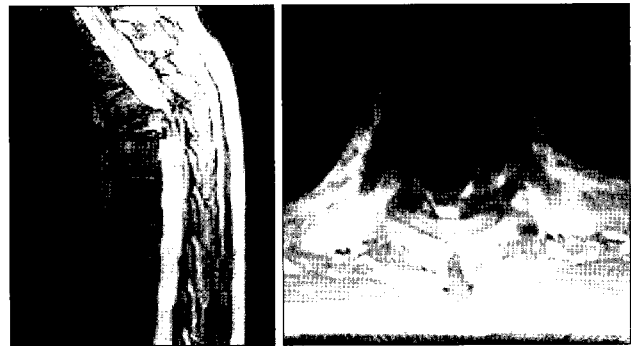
Thoracic magnetic resonance images show the thoracic kyphosis that resulted from a burst fracture at T4 body.
